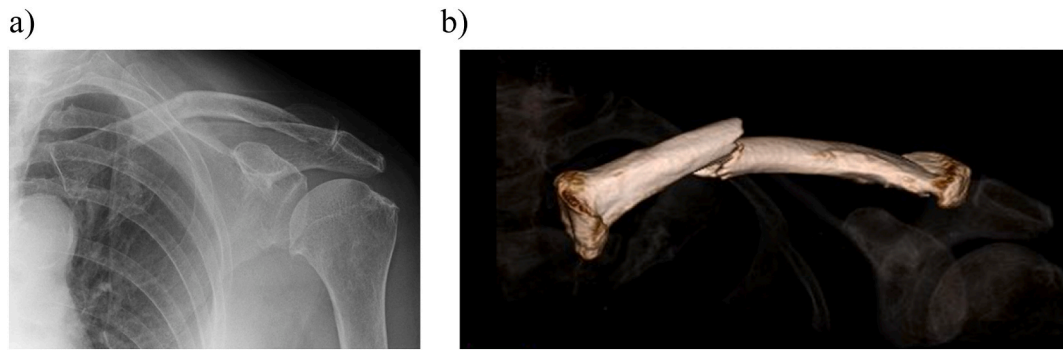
Preoperative imaging of the bipolar clavicle fracture; (a) X-ray of the bipolar clavicle fracture; (b) 3D reconstruction from computerized tomography scan image of the bipolar clavicle fracture.
